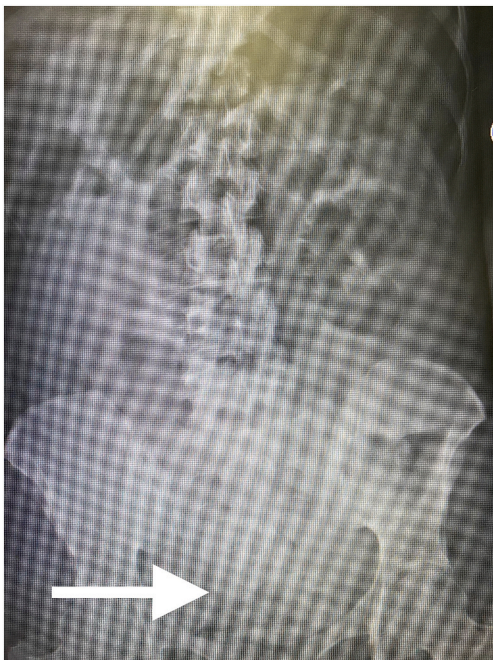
X-ray of the abdomen showing mildly dilated air-filled small bowel loops in the left upper quadrant measuring up to 4 cm. There is residual oral contrast within the rectum.
